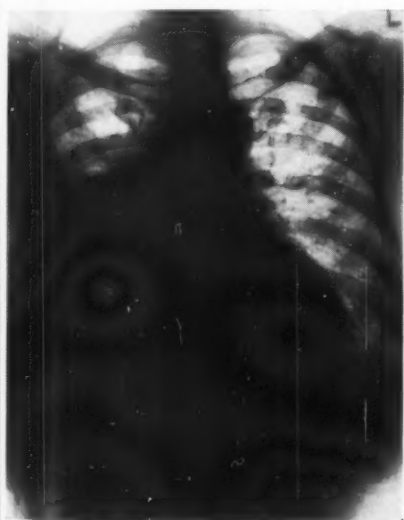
POSTERO - ANTERIOR RADIOGRAPH (4.9.50) SHOWING A RIGHT PLEURAL EFFUSION AND SLIGHT MOTTLING IN THE RIGHT UPPER ZONE. ROUNDED SHADOWS ARE ALSO PRESENT IN THE LEFT UPPER AND MIDDLE ZONES.
